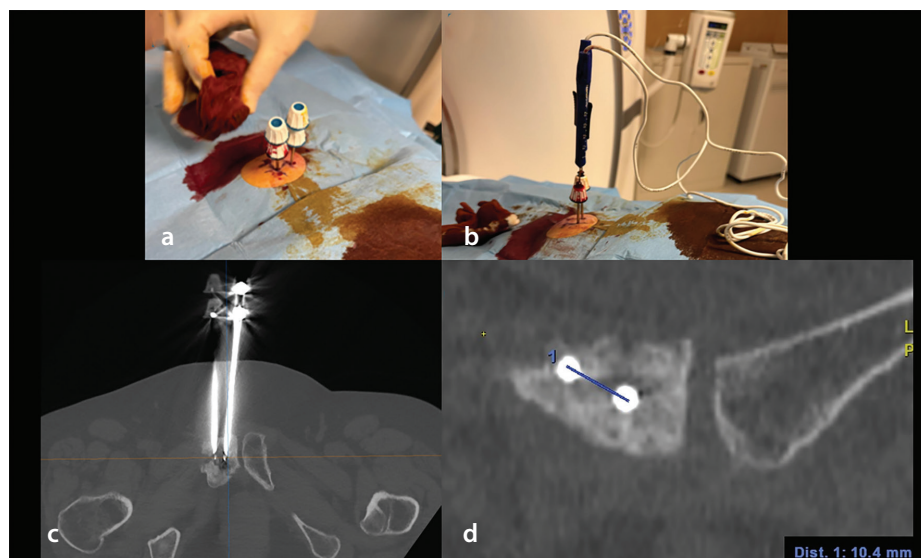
(a) Intraoperative view of the sterile setup showing the insertion of two Bonopt® 12-gauge coaxial bone access cannulae (Primed®) for a transosseous approach to the right pubic bone under CT guidance. (b) Intraoperative view showing coaxial insertion of the 19-gauge Nanoknife® IRE electrodes (AngioDynamics®) through the Bonopt® bone access cannulae. (c) Axial MIP reconstruction showing aligned placement of the right-sided 19-gauge IRE electrode targeting the osteolytic metastasis. (d) Coronal CT reconstruction demonstrating that the two IRE electrodes are positioned at an appropriate distance from each other, ensuring correct inter-electrode spacing for optimal electric field distribution. CT, computed tomography; IRE, irreversible electroporation; MIP, maximum intensity projection.
